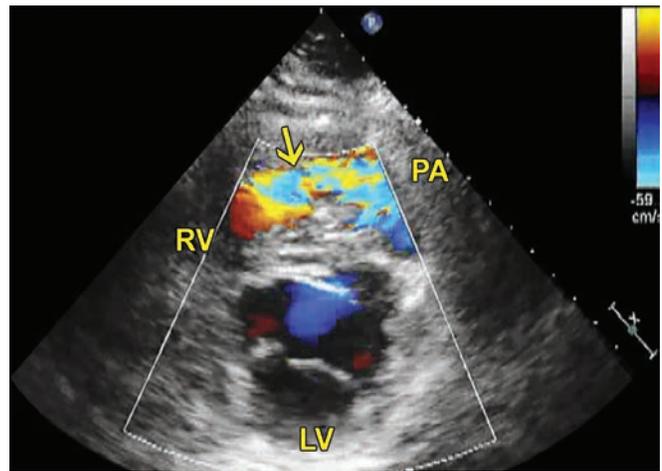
Color flow Doppler interrogation of the right ventricular outflow tract from parasternal short axis view (systolic frame shown).
